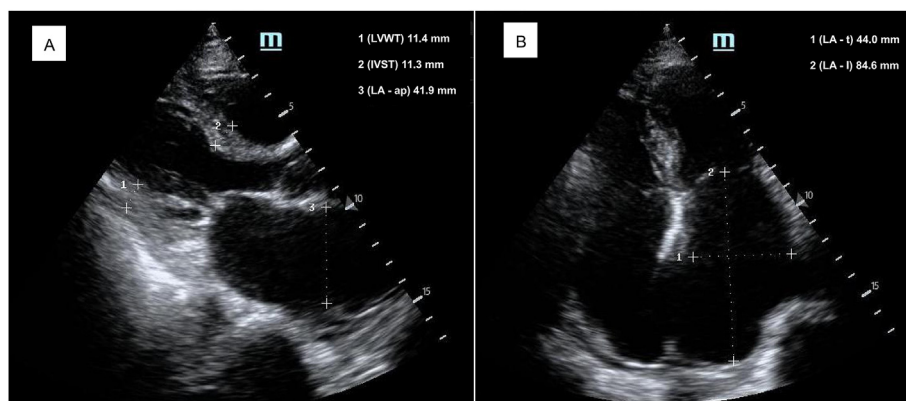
Bedside cardiac ultrasound images of a patient with HFHFS. A 85-year-old woman with hypertension developed HFHFS 20 h after surgery. The enlarged atria suggest preoperative chronic changes of the heart, which may contribute to HFHFS and subsequent acute cardiac dysfunction. A, Parasternal long-axis view; B, Apical four-chamber view. Abbreviations: LVWT, left ventricular wall thickness; IVST, interventricular septal thickness; LA-ap, left atrial anteroposterior diameter; LA-t, left atrial transverse diameter; LA-l, left atrial length.
